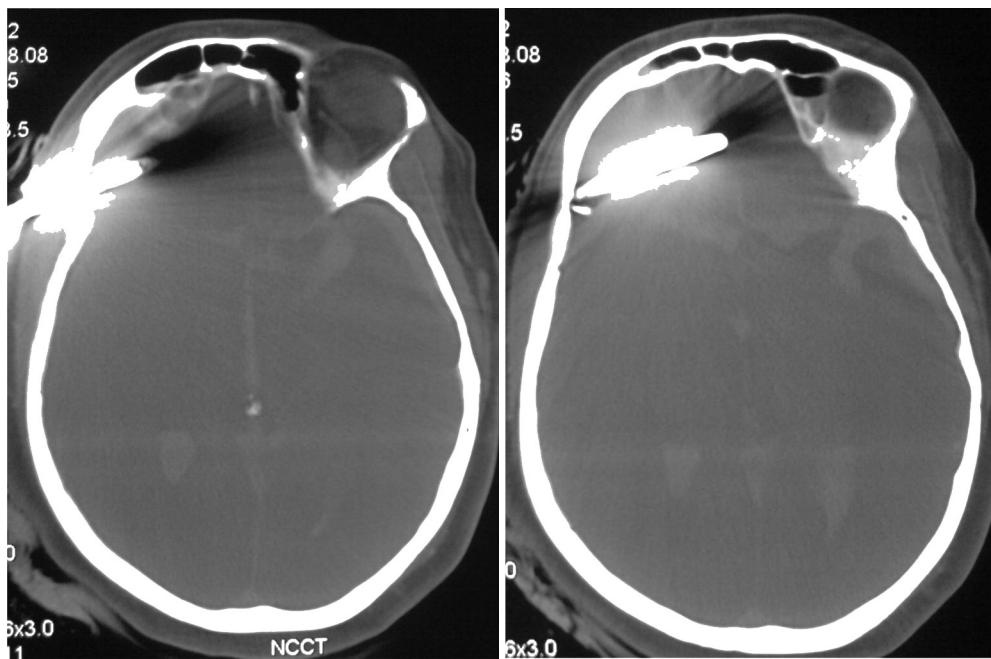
CT images of head showing screw driver in the cranial cavity.
